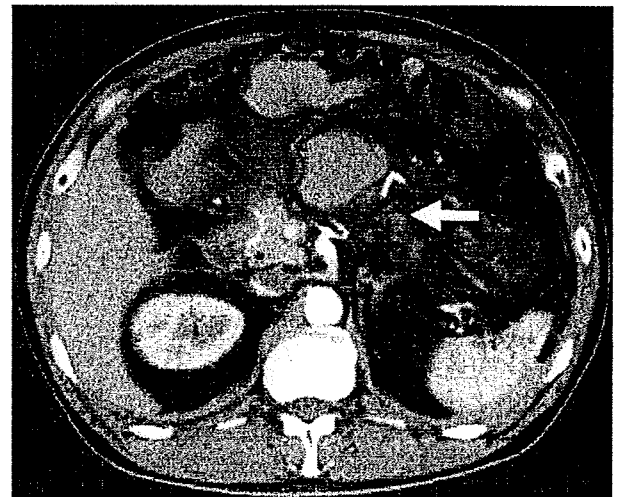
The successful embolization of the aneurysm of the middle-colic artery is shown on contrast-enhanced CT scan at 2 days after TAE (arrow)
